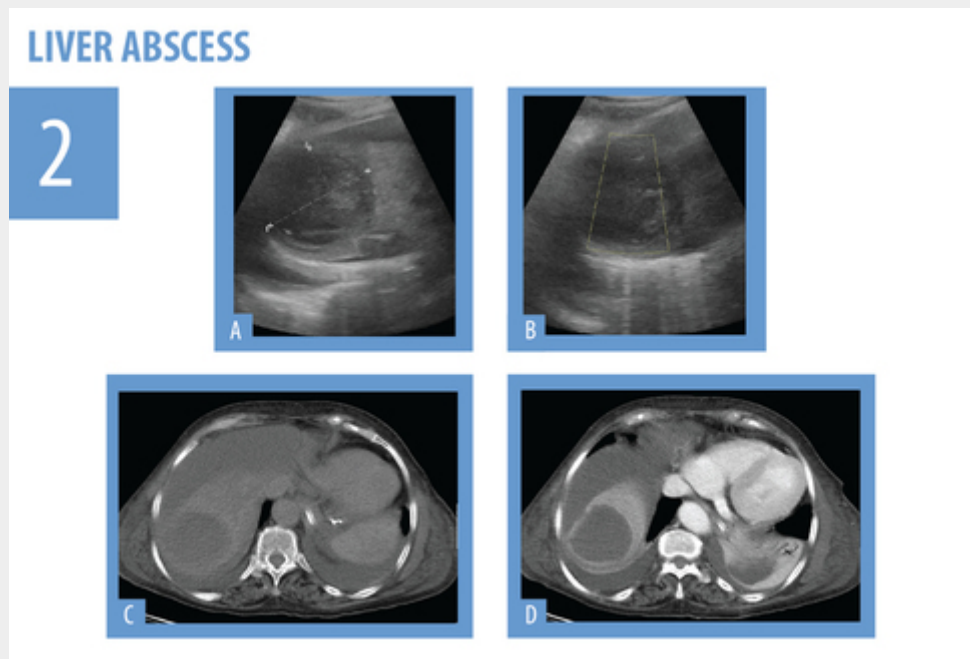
37 year-old intravenous drug user. He presented with fever, RUQ, loss of appetite. On US (A,B) there is a heterogeneous mass in the right liver lobe, in subcapsular location. This lesion also showed no internal Doppler sign. CT images (C,D) confirm the US findings, and also demonstrate perihepatic and perisplenic fluid.
